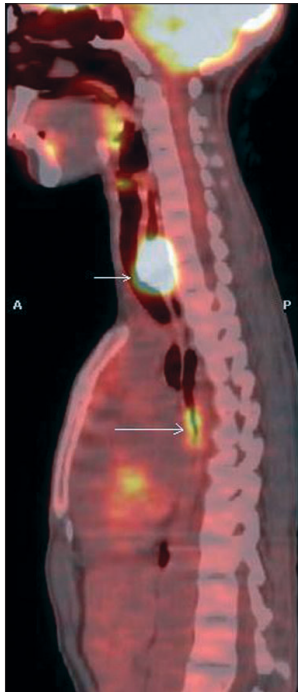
Coregistered sagittal PET-CT fusion image shows increased uptake in the primary esophageal mass (long white arrow) and the neck node (short white arrow).
